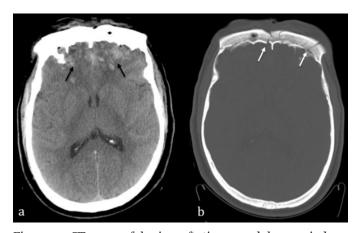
CT scan of brain soft tissue and bone windows showing bilateral frontal bone fractures with multiple bilateral hemorrhagic contusions, more on the left side. There is edema in frontal lobes with mass effect on frontal horns of both lateral ventricles.
